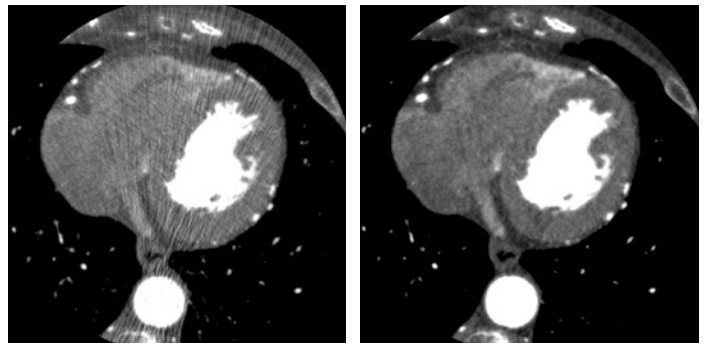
Cardiac CTA: FBP reconstruction (left) and AIDR 3D reconstruction (right), with a DLP of 29 mGy*cm and an effective dose of 0.4 mSv. Images courtesy of Monash Medical Center, Melbourne, Australia.
